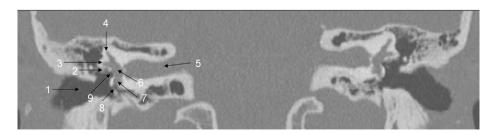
Coronal CT image demonstrating normal anatomy of the oval and round windows. 1. external auditory canal, 2. tympanic facial canal, 3. lateral semicircular canal, 4. superior semicircular canal, 5, internal auditory canal, 6. vestibule, 7. basal turn of cochlea, 8. round window niche, 9. oval window recess.
